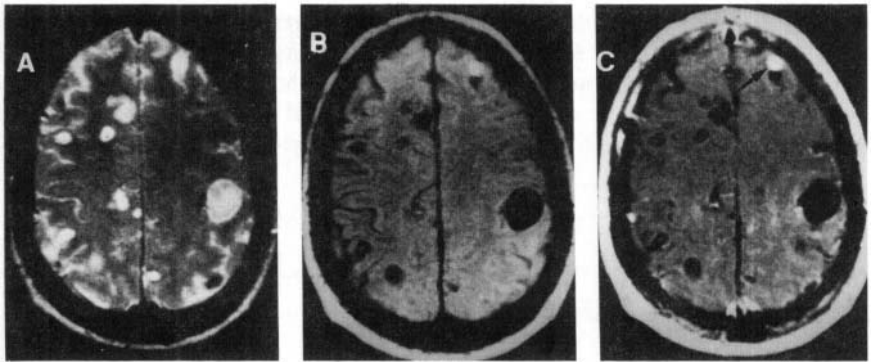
Neurocysticercosis with anterior cerebral artery territory infarction. T2-weighted axial image (a) shows evidence of an infarct in the left frontal region with multiple hyperintense cysts bilaterally. There is evidence of mild dilatation of left frontal horn. On T1-weighted image (b) the cysts appear hypointense. Some of the cysts show peripheral enhancement on postcontrast T1-weighted image (c). Note the focal enhancement along the left Sylvian fissure (white arrow).
